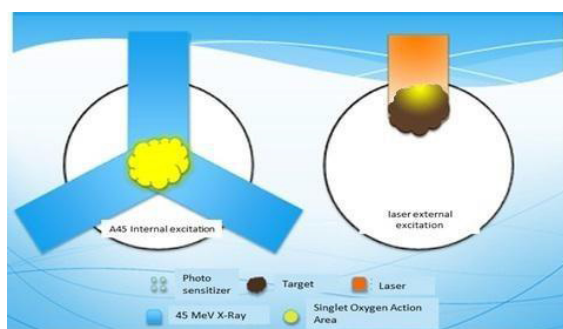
The comparison of the photosensitizer excitation effects by the internal Cerenkov light from 45MV x-rays in RDT and by the external laser light in PDT.
